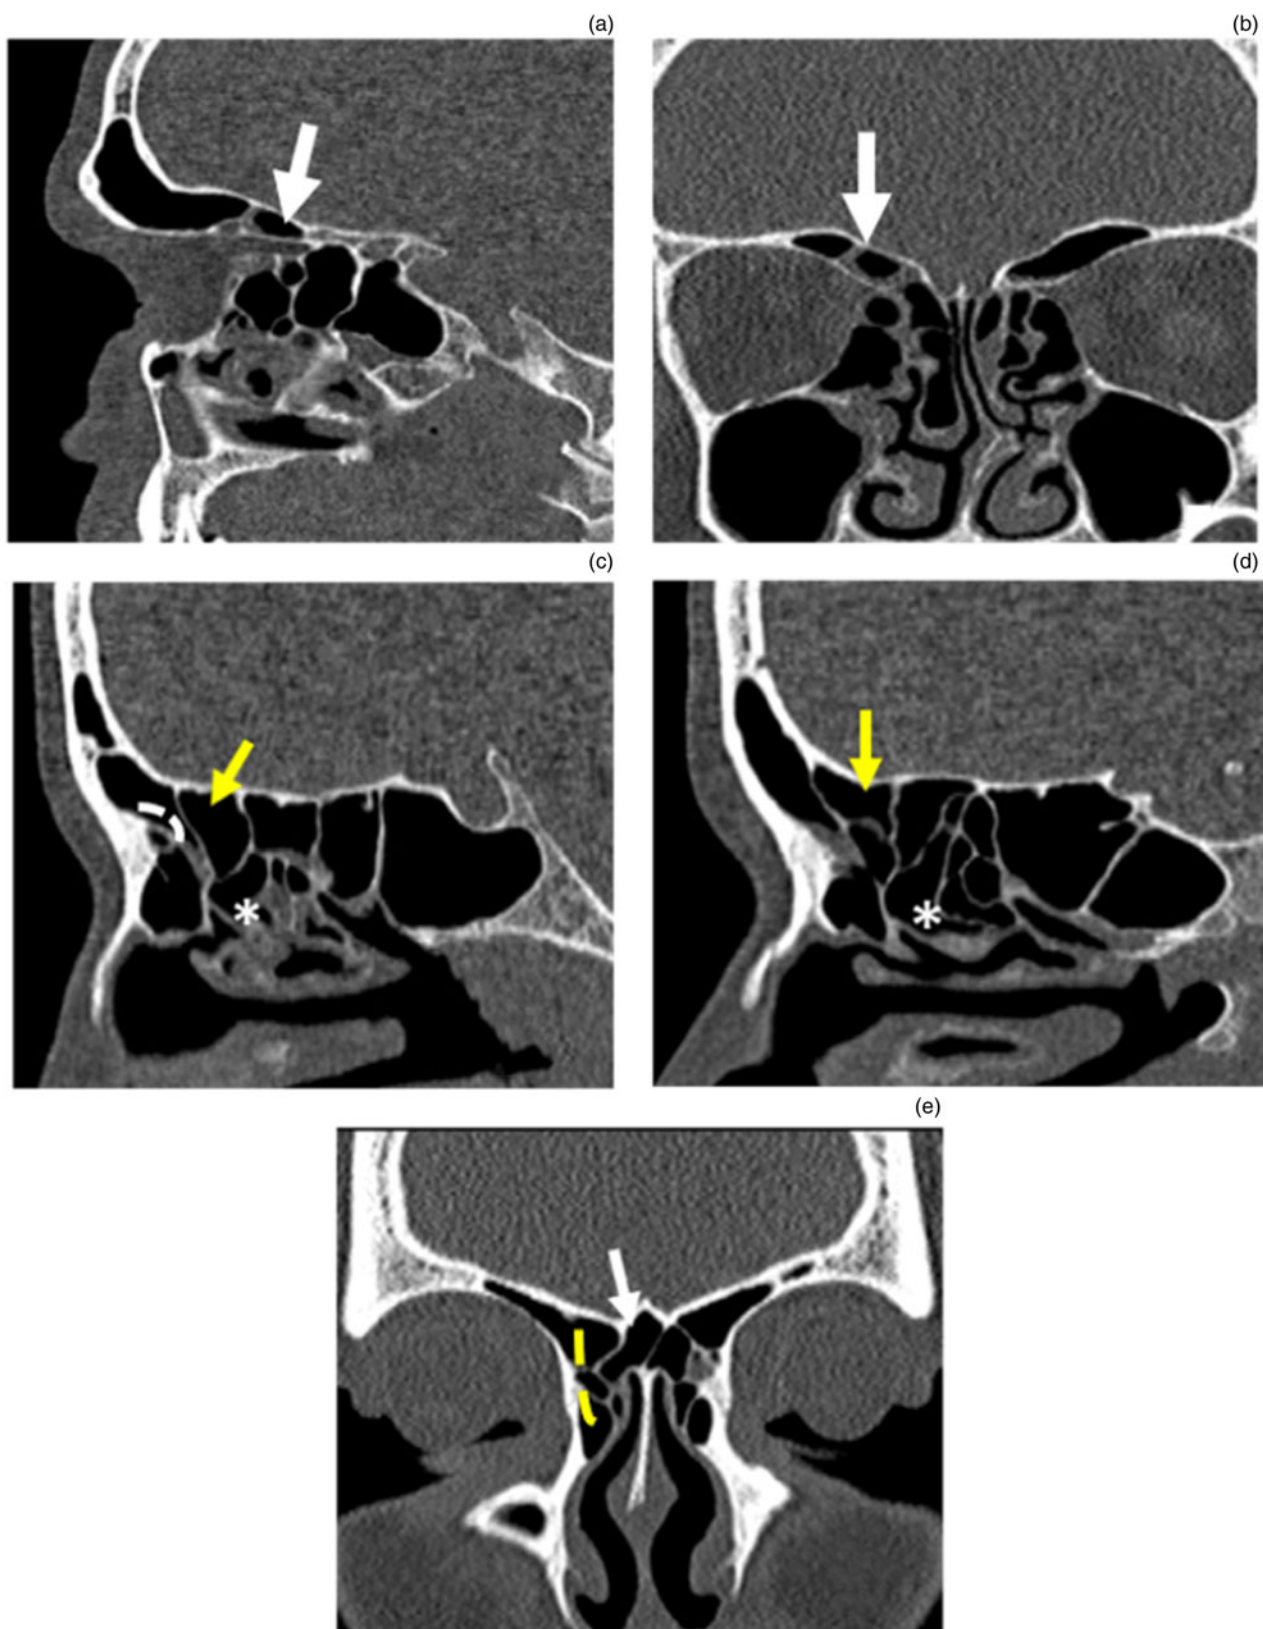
Posterior and medial International Frontal Sinus Anatomy Classification cells. Non-contrast sagittal (a) and coronal (b) computed tomography (CT) images of the paranasal sinus, showing a supra-orbital ethmoid cell (white arrow) in a patient with bilateral frontal sinusitis, which pneumatises over the orbit. Non-contrast sagittal CT images of the paranasal sinus of a different patient, showing a: (c) supra-bullar cell (yellow arrow), which lies above the ethmoid bulla (asterisk) pushing the frontal drainage pathway anteriorly (white dotted line); and (d) a supra-bullar frontal cell (yellow arrow), which lies above the ethmoid bulla (asterisk) pneumatising through the frontal ostium. (e) Non-contrast sagittal CT image, showing a right frontal septal cell (white arrow) attached to the inter-frontal sinus septum.
